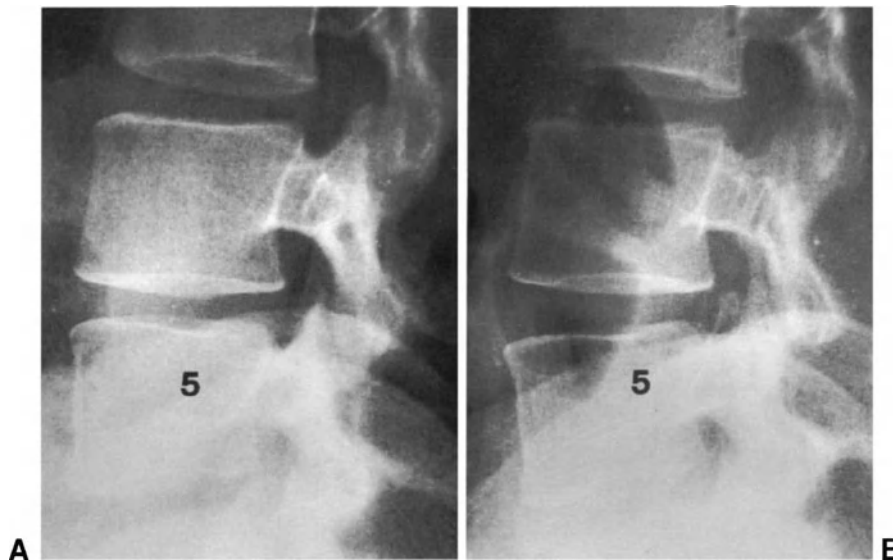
Plain radiographs of a patient submitted to chemonucleolysis at L4-L5 level. (A) 1 month after the procedure. (B) 1 year after the procedure; the height of the L4-L5 disc is comparable to that before nucleolysis and that of the disc above.
